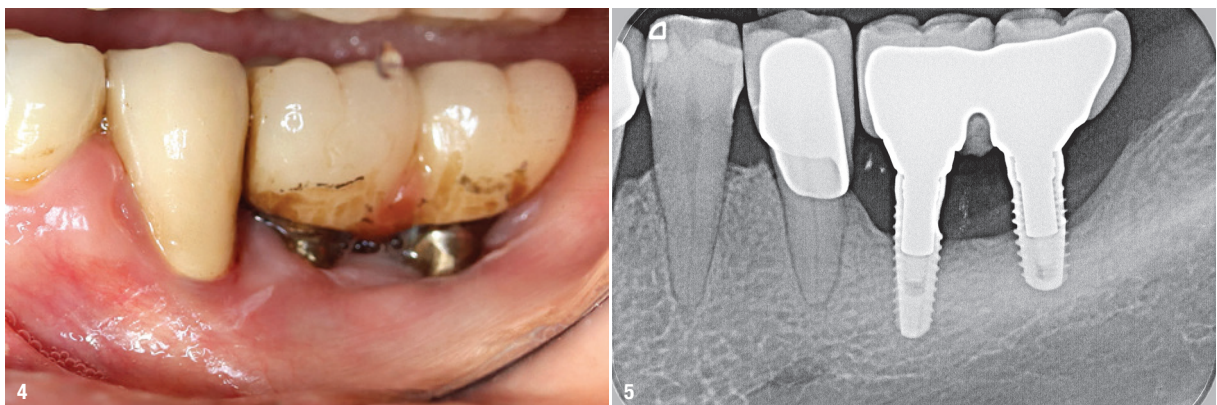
In this peri-implantitis patient (heavy smoker, moderate oral hygiene), small successes could be achieved through early scaling and root planing, and thus the situation was kept largely stable. Nevertheless, smoking cessation and an improvement in oral hygiene should be aimed for in order to achieve greater success. Fig. 5: Radiographic image of the same patient as in Figure 4.
